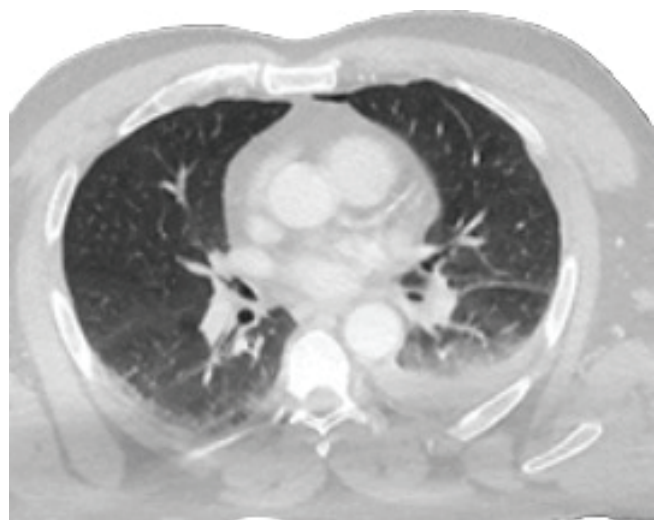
Thoracic CT scan of the patient taken after trauma.
